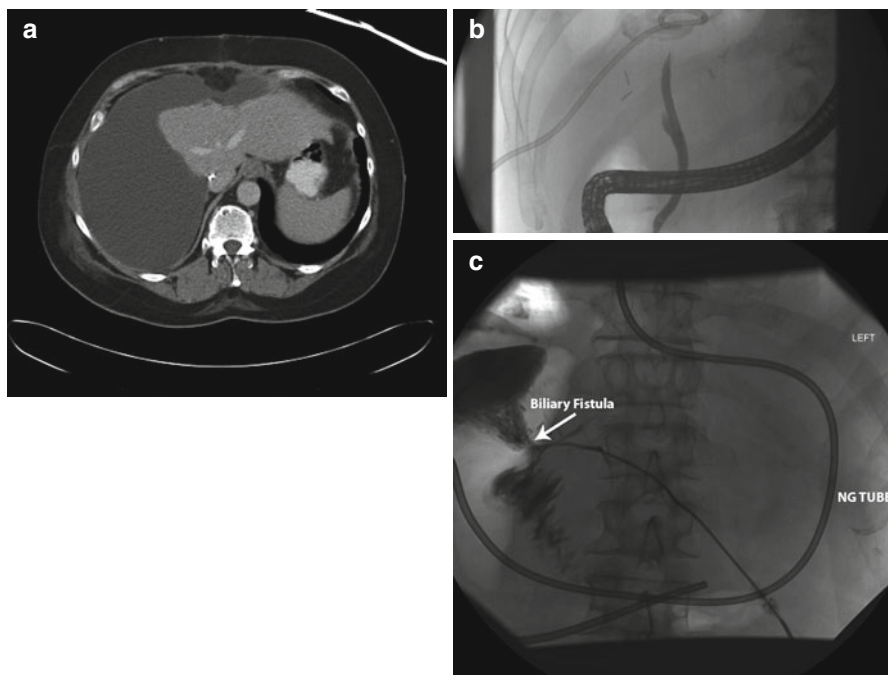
(a) CT scan demonstrating a large parahepatic fluid collection following right hepatectomy. Percutaneous drainage was undertaken confirming a biloma. (b) Endoscopic retrograde cholangiopancreatography (ERCP) from the same patient showing non-filling of the proximal hepatic ducts confirming a stenosis of the common hepatic duct. (c) Percutaneous transhepatic cholangiogram showing a nasogastric tube in situ (NG tube) and contrast leak confirming a proximal biliary fistula. The patient was treated with a Roux-en-Y hepaticojejunostomy
